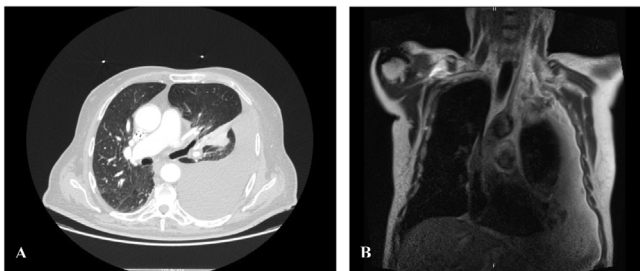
Computed tomography (CT) scan (A), Chest MRI (B). Mediastinal pleural mass associated with extensive pleural effusion on the left.
